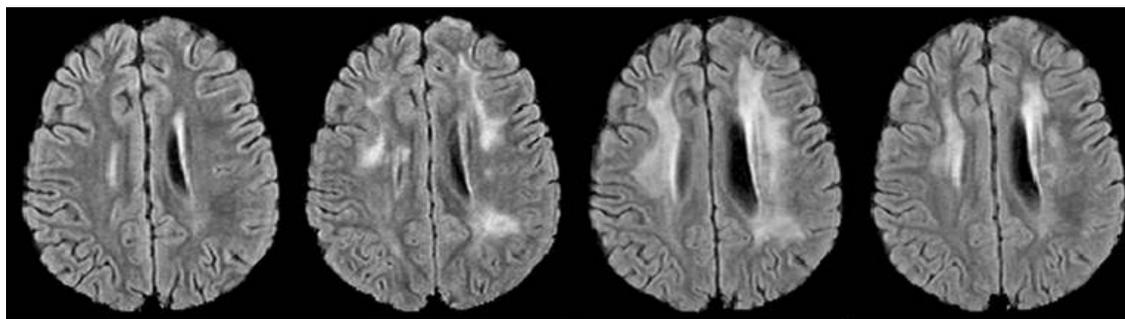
MRI FLAIR (fluid attenuated inversion recovery) images of changing patterns of leukoencephalopathy in ALL associated with HDMTX (high dose methotrexate). From left to right: Week 7 (1 HDMTX), Week 18 (4 HDMTX), Week 44 (7 HDMTX), and Week 132 (end of treatment). The transverse images show periventricular white matter abnormalities increasing to 35% of total white matter volume at Week 44 and then decreasing to 15% at the end of treatment (Reddick et. al., Quantitative MR measure of MTX neurotoxicity in children, in press).
